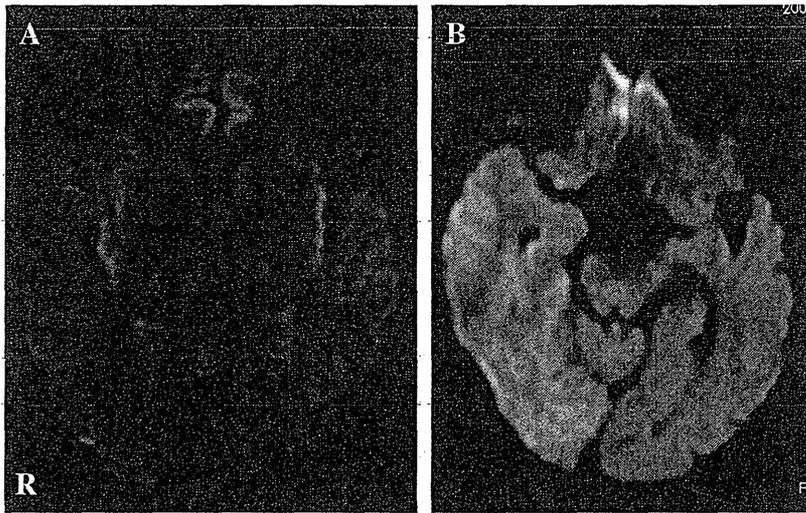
Diffusion-weighted MR images (axial images) in NHLE patients (patients 1 and 2). Brain MRI shows high signal intensities on diffusion-weighted images in the bilateral medial temporal lobes, cingulate gyri, and insulae in patient 1 (A; cited from reference [21]. Adapted with permission.) and in the right temporal and occipital lobes in patient 2 (B).
